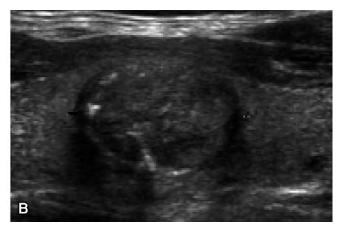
8. Using color Doppler, the peripheral hypoechoic halo especially found in follicular tumors represents peripheral vessels adjacent to the capsule [6,7]. A thin, even halo with a thin vascular rim is strongly indicative of a follicular adenoma (FA). A thick halo usually corresponds with a thick rim of vessels. An even or uneven
